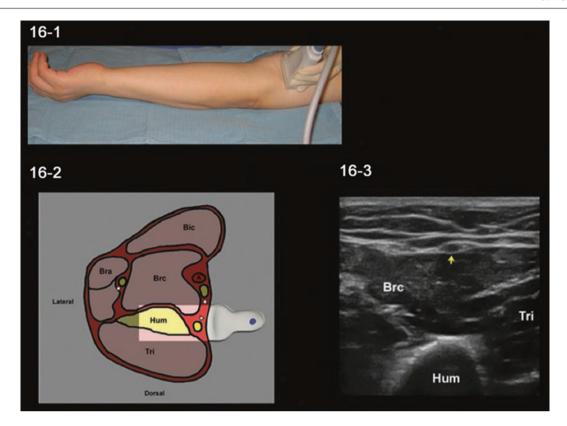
Median nerve block in the distal arm. (1) Ultrasound probe placement. (2) Anatomical structures within the ultrasound transducer range. (3) Ultrasound image of median nerve (*arrowhead*) in the distal
